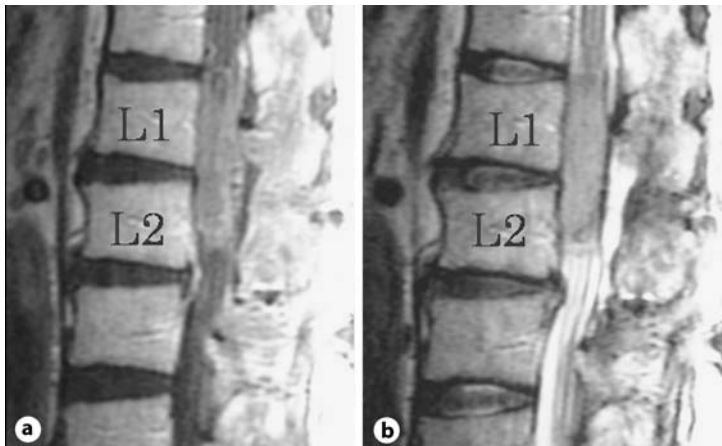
Spinal MRI demonstrated an intraspinal tumor extending from the Th12 to L2 level. The tumor showed high intensity on T1-weighted image (a) as well as on T2-weighted image (b).
